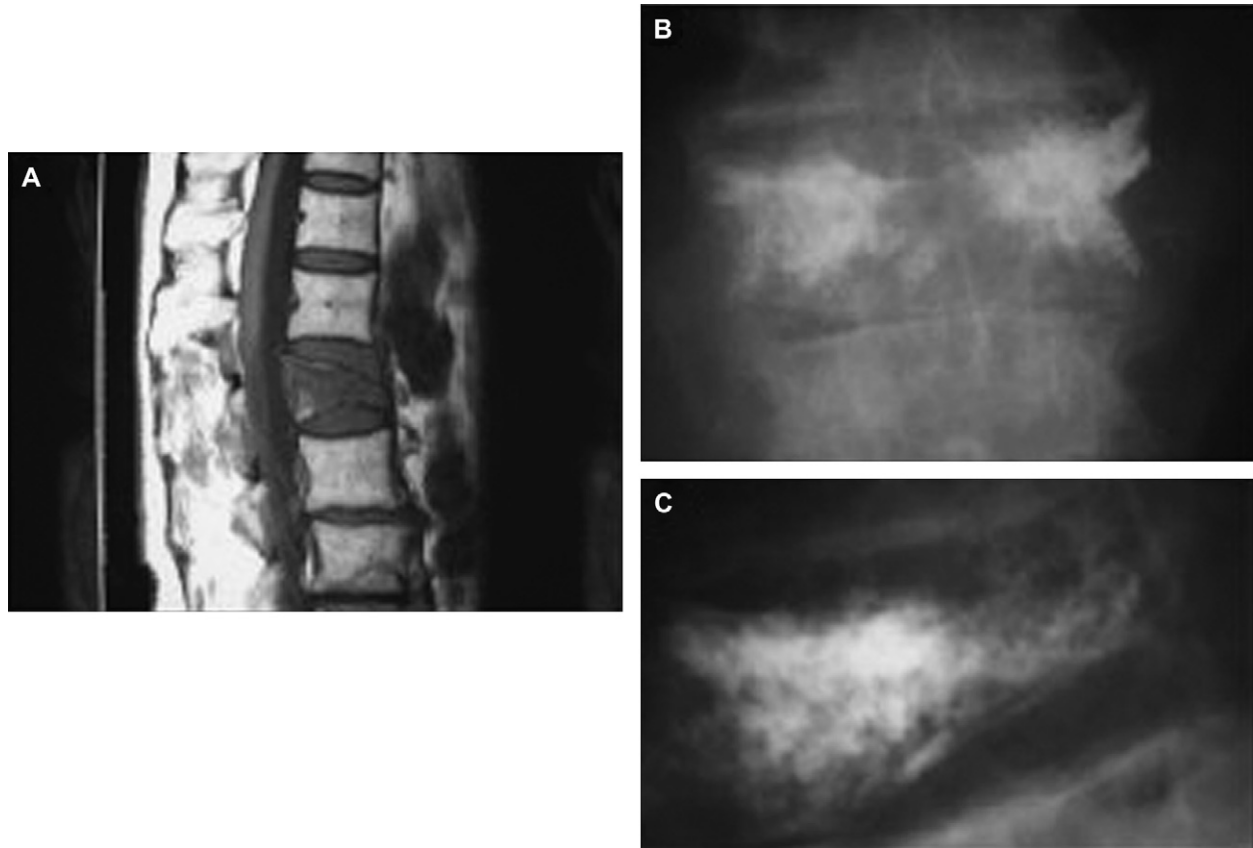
Magnetic resonance imaging and X-ray films showing (A) pre- (B, C) and postoperative films of an L1 compression fracture. (A) Magnetic resonance imaging showing marrow edema in a subacute VCF. (B) AP and (C) lateral postoperative X-ray films showing a bilateral vertebroplasty.
